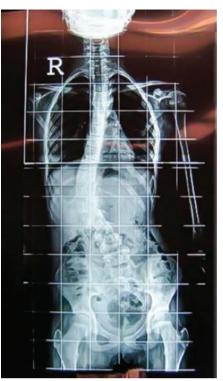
Standing AP spine x-ray
